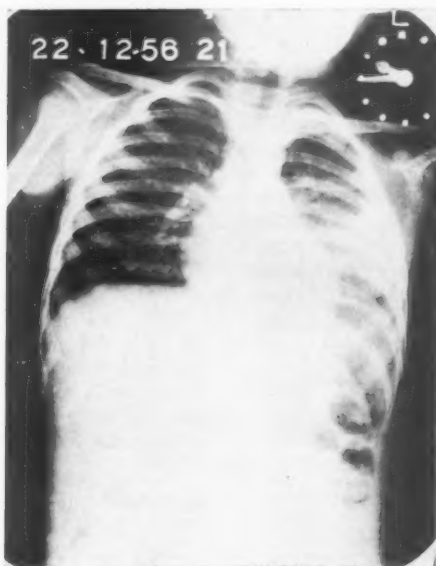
Radiograph of the same child as Fig. I., one week later after several aspirations had been undertaken.
